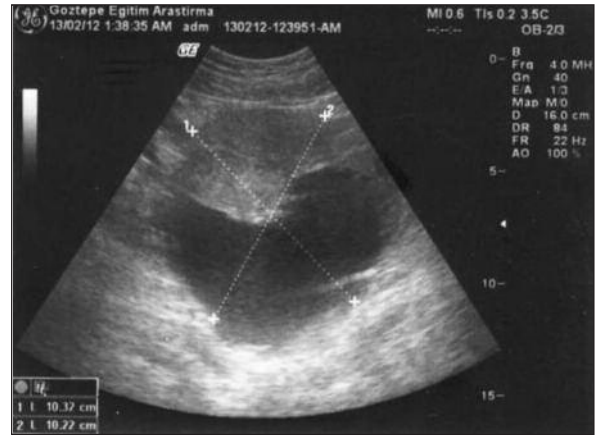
Abdominal ultrasound view, a solid-cystic right adnexial mass.
